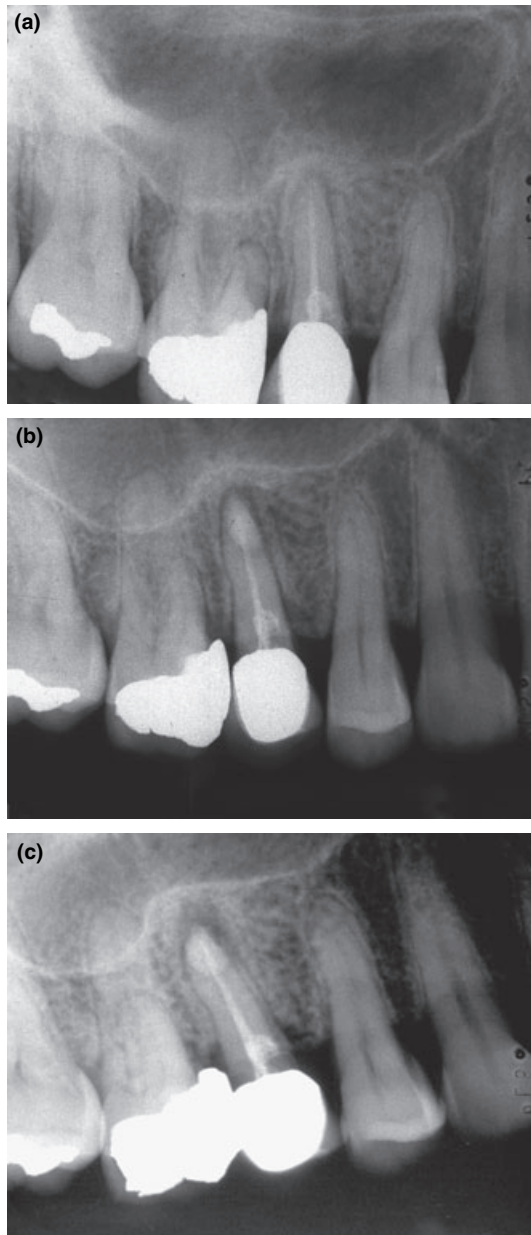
Example of incomplete healing. Radiographs taken preoperatively (a), postoperatively (b), at 1-year follow-up (c) and at final examination after 8 years (d). Please notice decreased size and irregular outline of radiolucency located asymmetrically at tooth apex.
